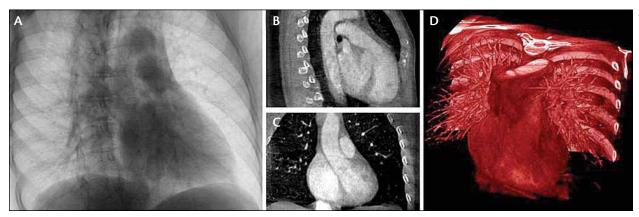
A C-arm CT prototype system was used to create this series of images. Panel A shows a frame from the rotational angiogram involving 180° rotation immediately after central venous contrast injection. Panels B and C show two corresponding slices from the resulting cone-beam 3D reconstruction. Panel D shows the 3D volume rendering. Reproduced with kind permission from Springer Science+Business Media: Int J Cardiovasc Imaging, Potential role of three-dimensional rotational angiography and C-arm CT for valvular repair and implantation, 2011;27:1205–1222, Schwartz JG, Neubauer AM, Fagan TE, et al.²⁷
